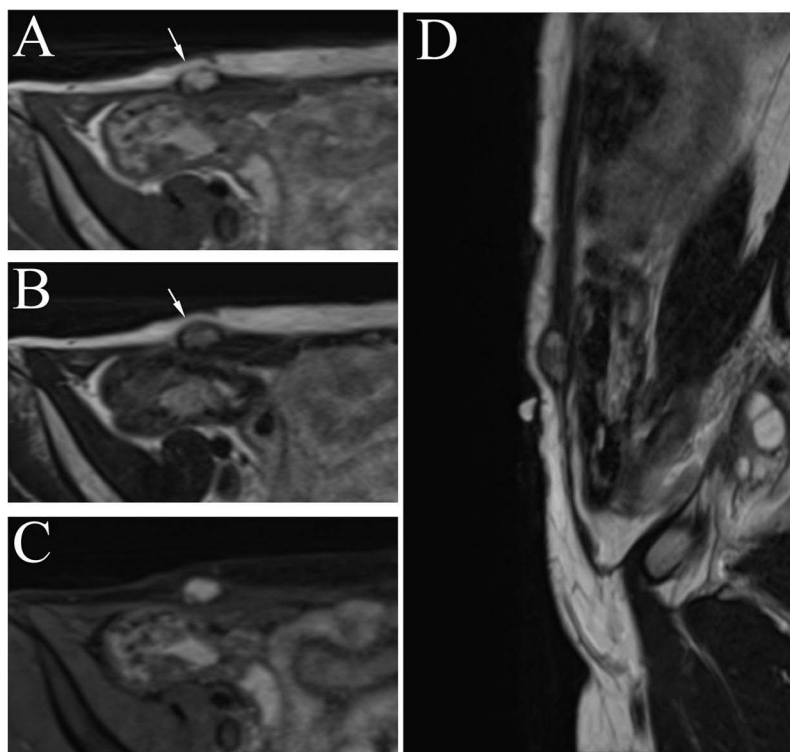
A 32-year-old woman with a mobile mass of the right abdomen (Case 4). The patient did not undergo cesarean section. Preoperative magnetic resonance imaging showed a 1-cm well-defined mass over the right rectus abdominis muscle. On T1- and T2-weighted images, the tumor was hyperintense compared with the muscle ((A and B); arrow). The signal was not reduced on fat-suppressed images (C). Sagittal section of the abdomen showed no continuity between the tumor and right inguinal canal (D).
